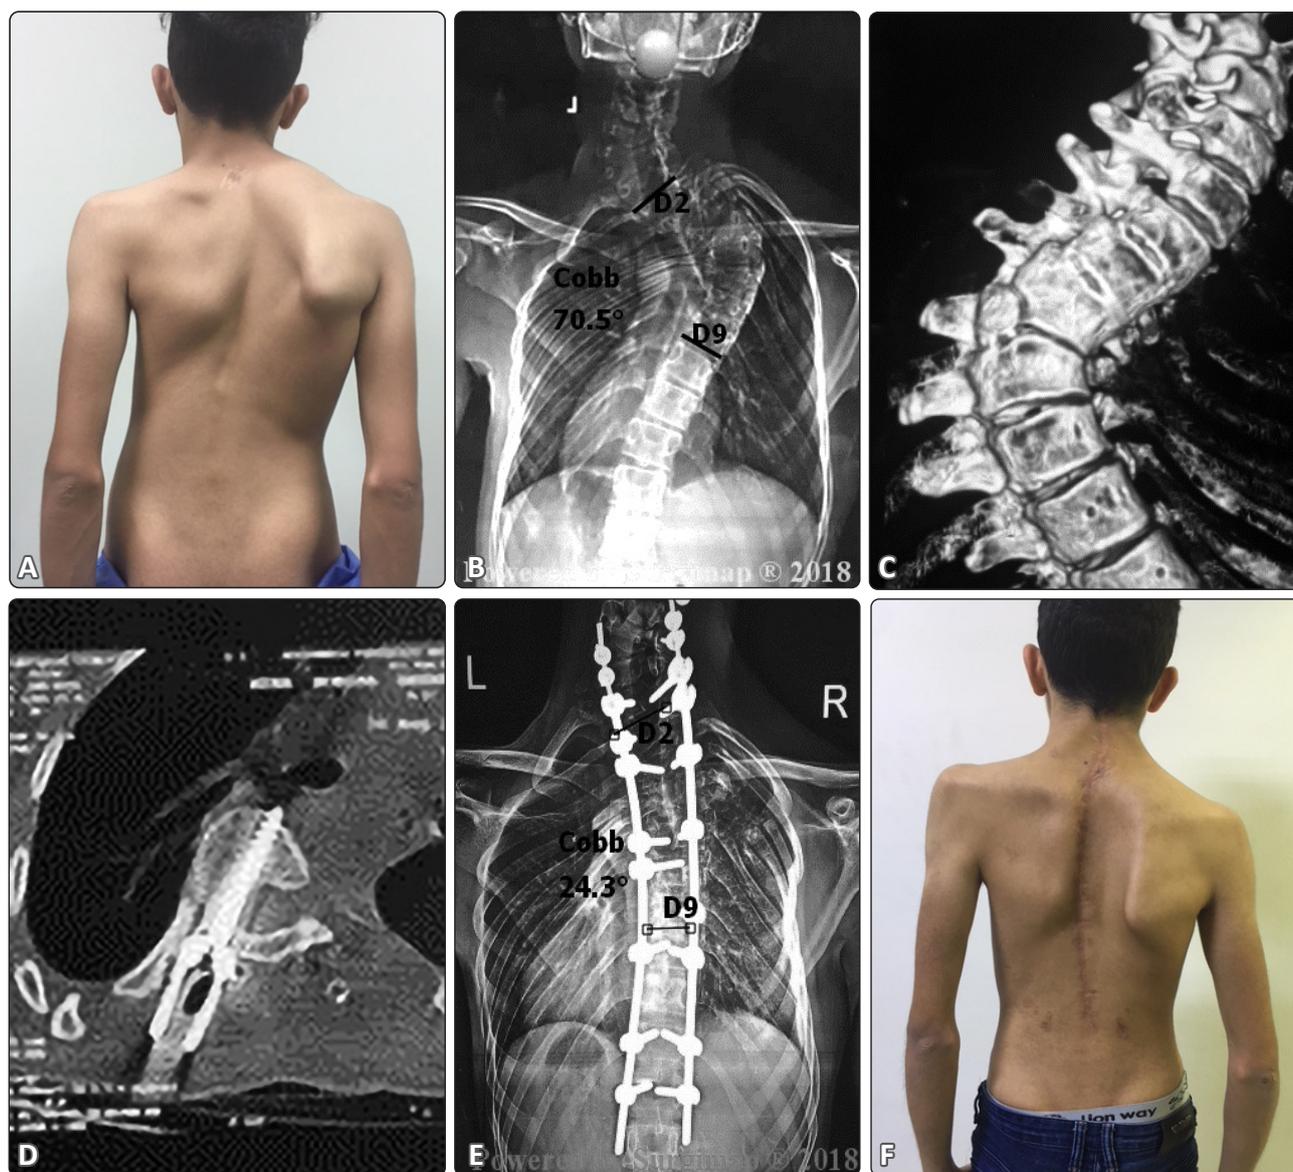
(A) 17-year-old male patient complaining of right rib hump. (B) Plain X-ray film of the cervical and thoracic spine showing cervicothoracic scoliosis. (C) 3D CT reconstruction of the deformity showing a hemivertebra at the apex of the deformity (D5-6) with fused intervertebral discs in the adjacent proximal segment. (D) Axial CT cut after the first operation showing one of the malpositioned screws that was corrected in the second session without sequelea. (E) Postoperative plain X-ray showing satisfactory correction after removal of the apex in the second session. (F) Postoperative clinical photo with satisfactory correction of the rib hump but with unbalanced shoulders (cosmetic complication).
